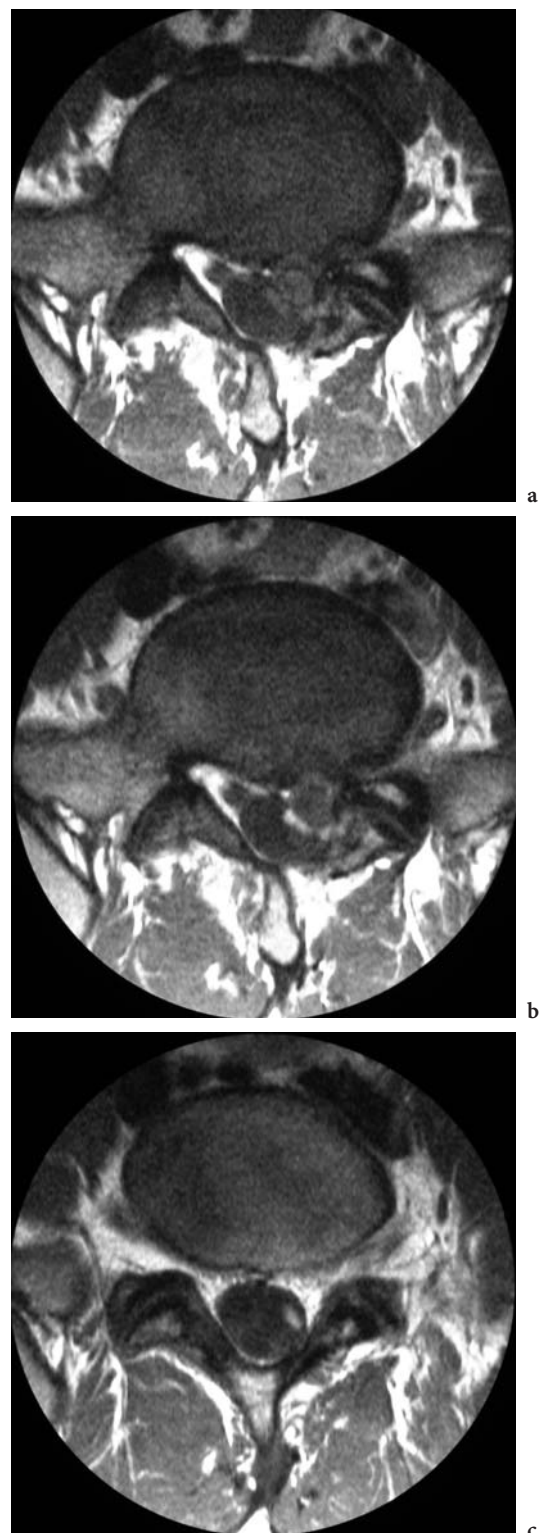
Recurrent disc herniation with radiculitis. Axial T1-WI (a), axial T1-WI after gadolinium enhancement (b) and axial T1-WI after gadolinium enhancement above the surgical level (c). Patient 6 months after surgery with recurrent leg pain. MRI shows the typical image of a recurrent disc herniation. The enhancing tissue posteromedially and intrathecally does not represent scar tissue but are actually enhancing nerve roots. These can be traced upwards (c), sometimes all the way up to the conus medullaris
